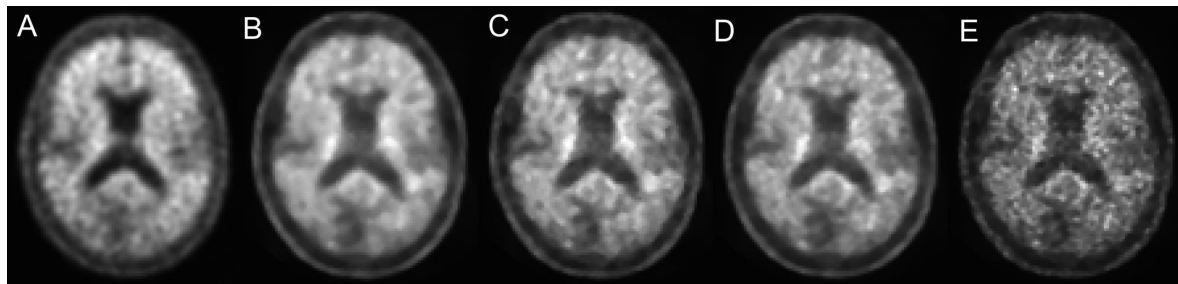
Example of a patient with AD pathology acquired on (A) PET/CT, (B) CMB with 2mmPSF, (C) CMB with 2mmNoPSF, (D) CMB with 1mmPSF, (E) CMB with 1mmNoPSF. The Centiloid values were equal to: (A) 106, (B) 103, (C) 111, (D) 94, (E) 105. From “*Amyloid brain-dedicated PET images can diagnose Alzheimer’s pathology with centiloid scale.*” by Maria Teresa Gandia-Ferrero, Irene Torres-Espallardo et al. 2024. Copyright by Physica Medica.
